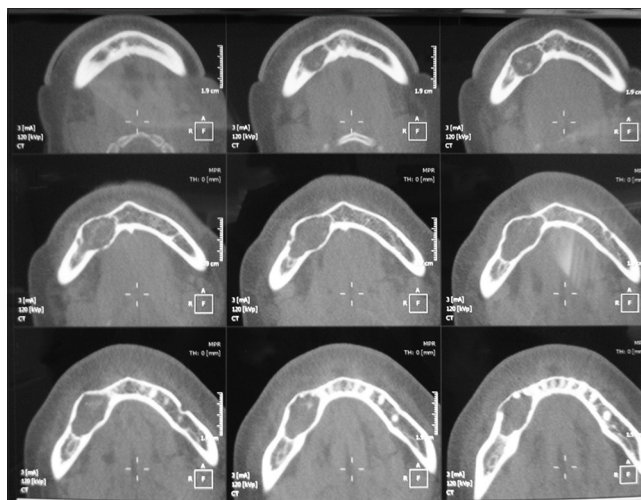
Noncontrast axial computed tomography at bone algorithm showing a tumoral mass occupying the posterior part of the right mandible
